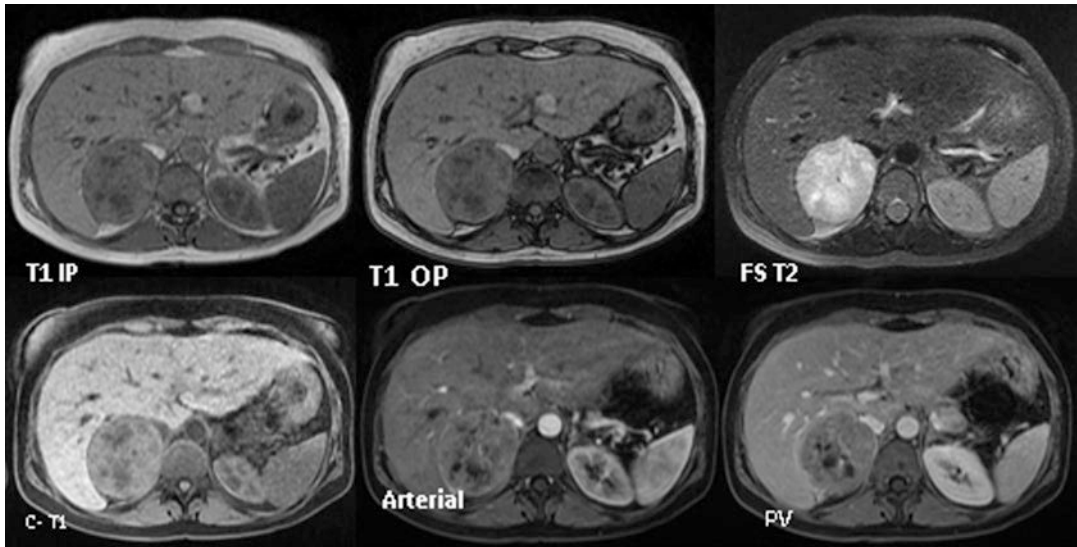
Right adrenal mass in MRI images. *OP* out of phase, *IP* in phase, *FS T2* fat sat T2, *PV* portal venous phase
